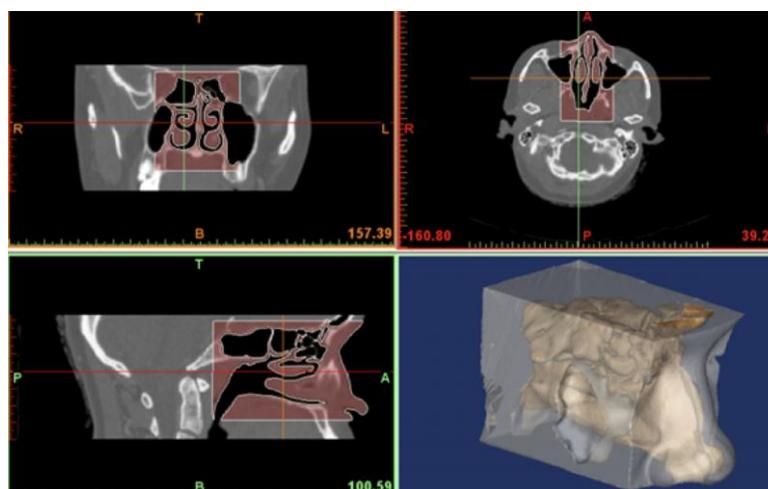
CT scan images and 3D model of human nasal cavity (13)
